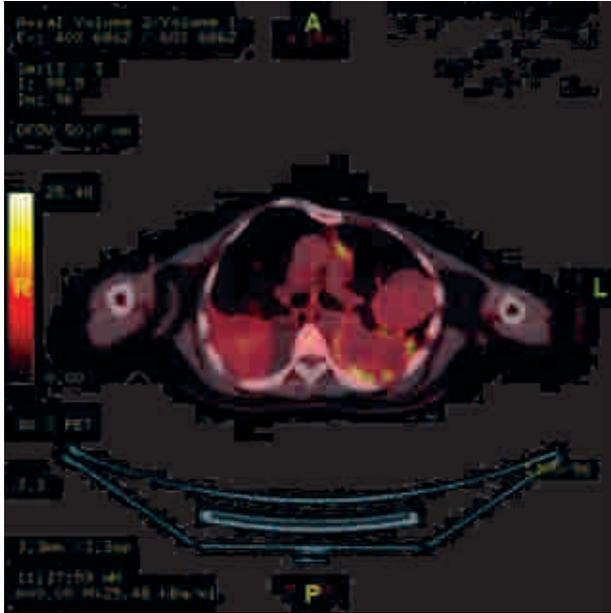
NM PET Scan Validating the Findings of the CT Scan and Additionally showing Increased Uptake in the Pleura Indicating Pleural Involvement as Well
